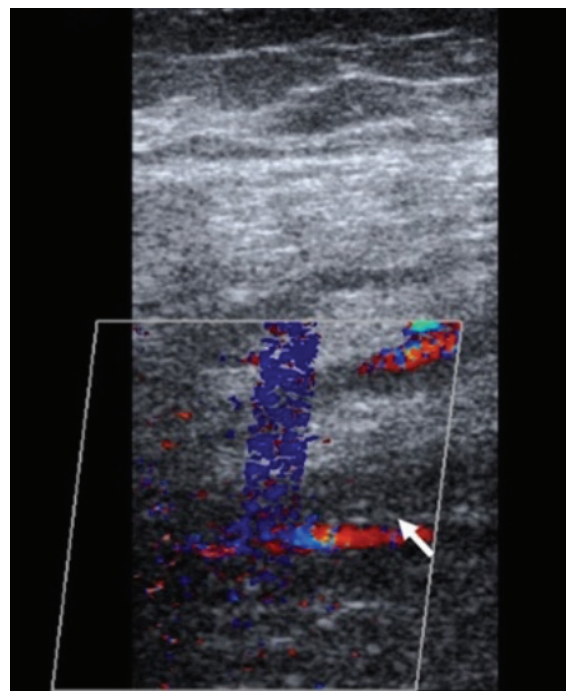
Doppler US of a recently operated 48-year-old female with deep venous thrombosis of the posterior tibial vein
